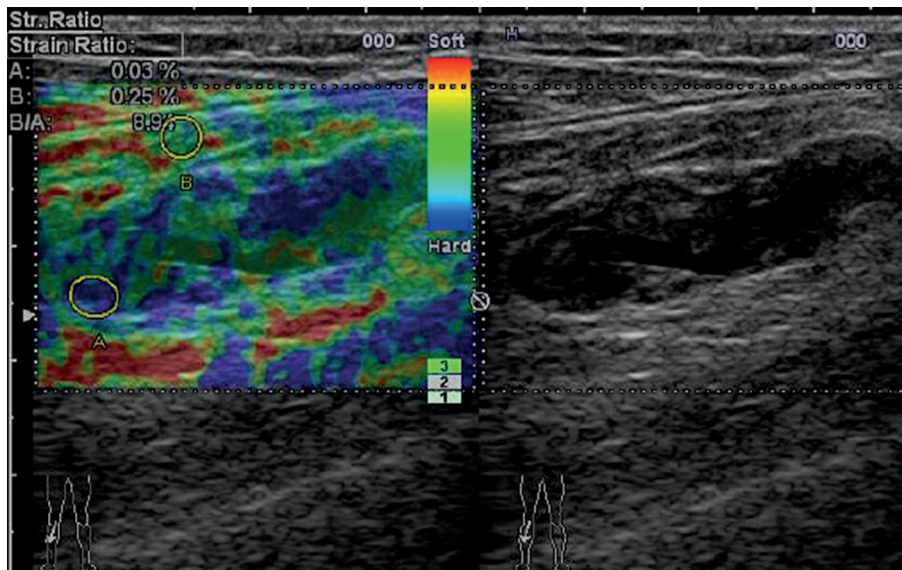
Ultrasound elastography image of chronic thrombosis.
